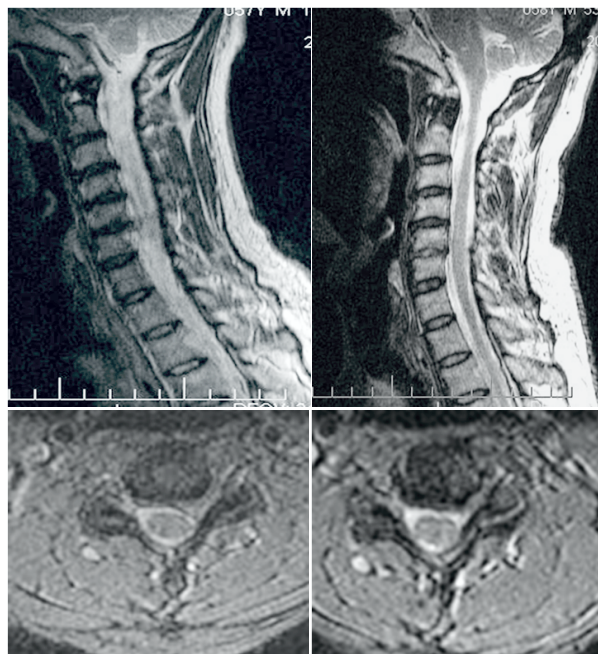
Pre and post op MRI showing removal of herniated disc.
